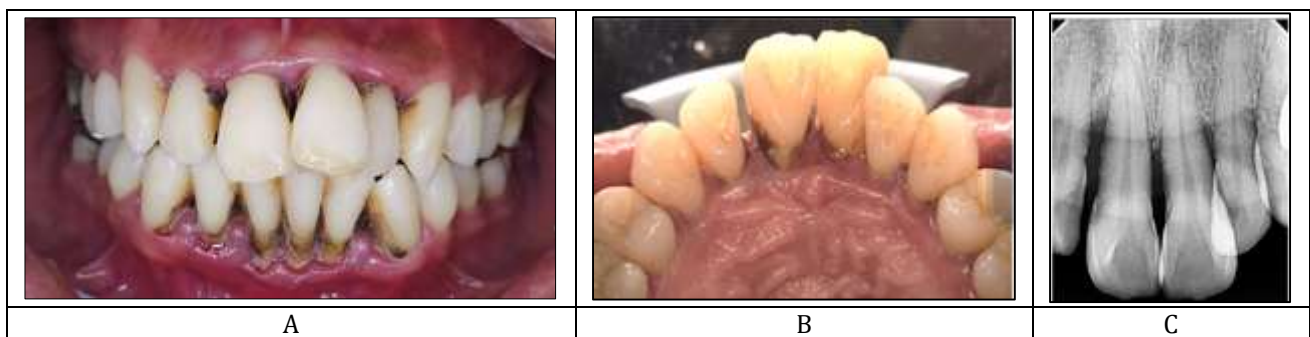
Baseline. (A & B) Clinical photographs. (C) Periapical radiograph of tooth 11 tooth 21
